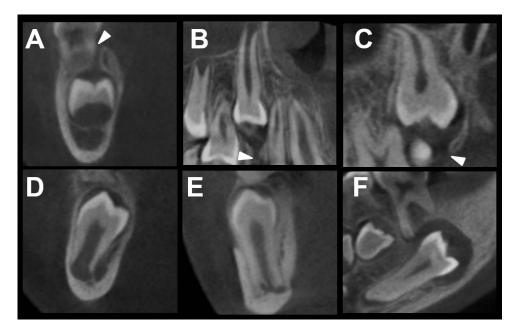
CBCT images of the gubernacular canal (GC) detected in (A) teeth with normal eruption, (B) teeth with delayed eruption, and (C) impacted teeth (arrows indicate GC opening in the alveolar crest). GC not detected in (D) normal eruption, (E) delayed eruption, and (F) impacted teeth.
